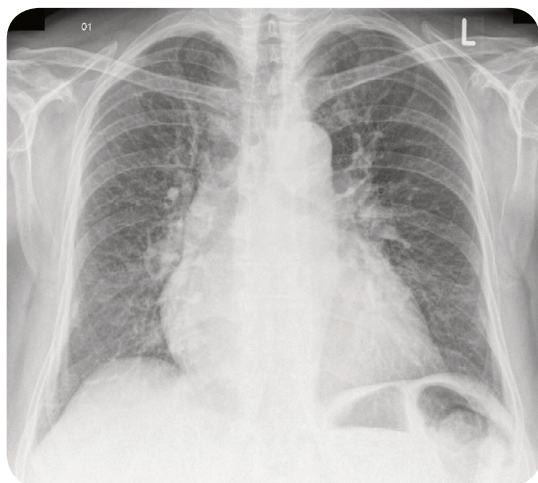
A plain chest X-ray image demonstrating pulmonary edema. The vessels at the hila are prominent and there are numerous Kerley B lines.
